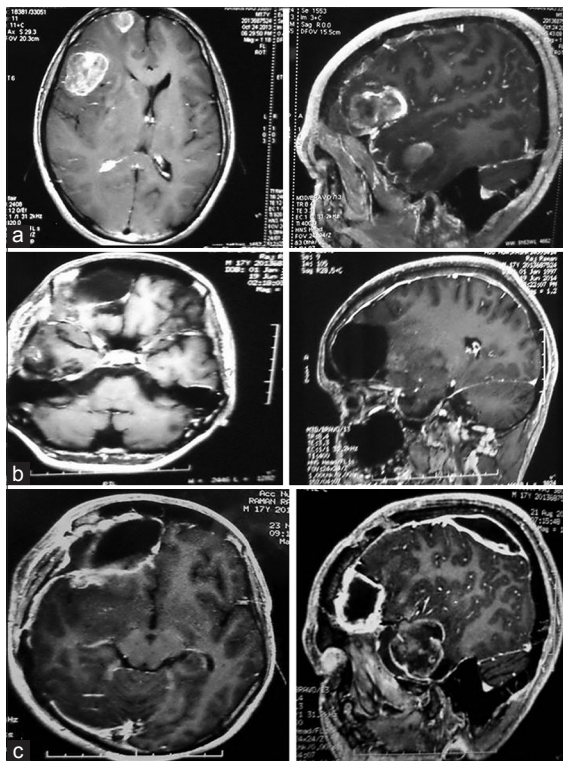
Magnetic resonance imaging contrast showing multicentric glioblastoma (a), postoperative image (b) and recurrence at same site as well as ipsilateral parietal lobe after 1-year of surgery (c)
